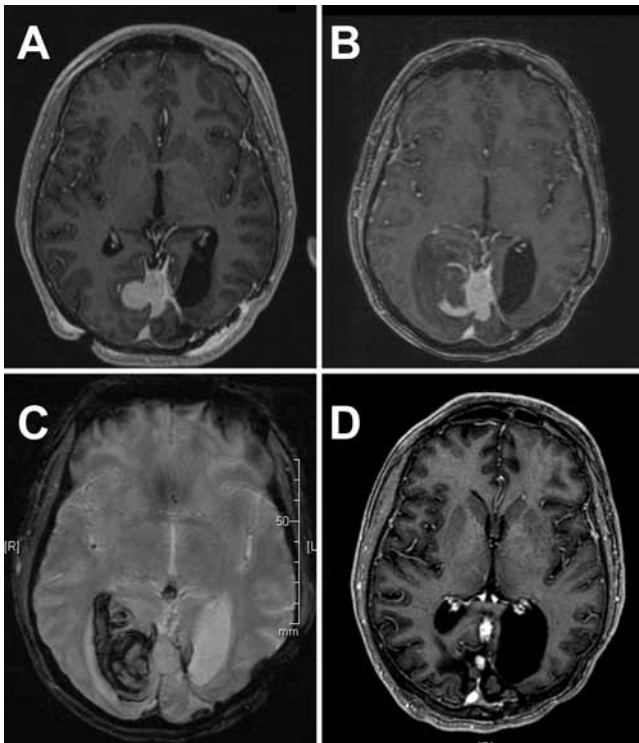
Case 2. Axial post-Gd T1-weighted MR image (A) obtained 3 months after an initial resection, demonstrating a homogeneously enhancing nodular tumor arising from the occipital falx near the falco-tentorial junction. Follow-up image (B) obtained after 1 year showing recurrent tumor growth and hemorrhage into the adjacent occipital lobe, better seen on a gradient-echo weighted sequence (C). Follow-up image obtained after 58 months, demonstrating a local small nodular recurrence (D).
